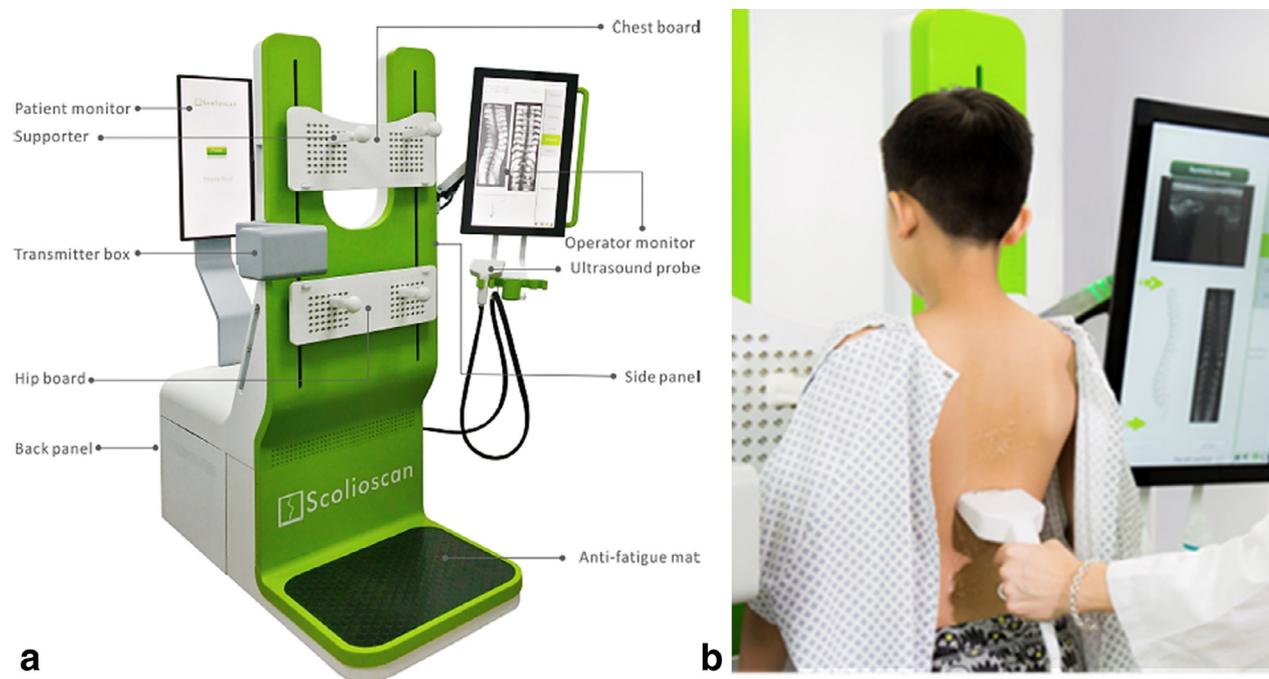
(a) The Scolioscan system with its components labeled. The ultrasound scanner, computer and spatial sensor control box were installed inside the device. (b) Ultrasound assessment for a patient.
